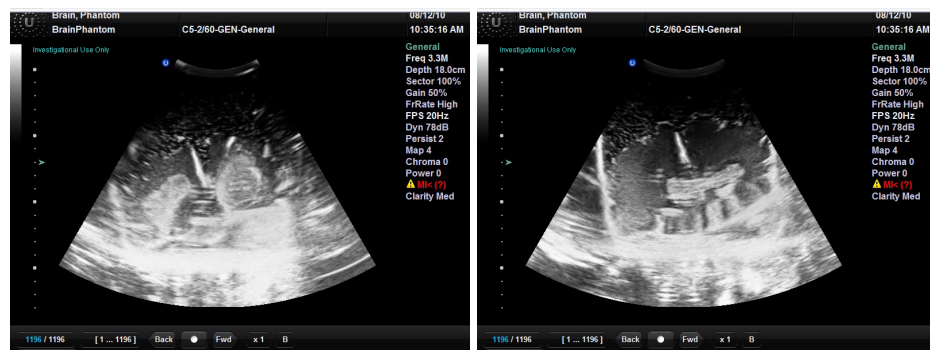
The B-Mode Ultrasound images show parts of the internal structure, the left image shows a slice through the cerebellum, the right displays the pons in the middle, furthermore the interbrain, midbrain and the balloon.
